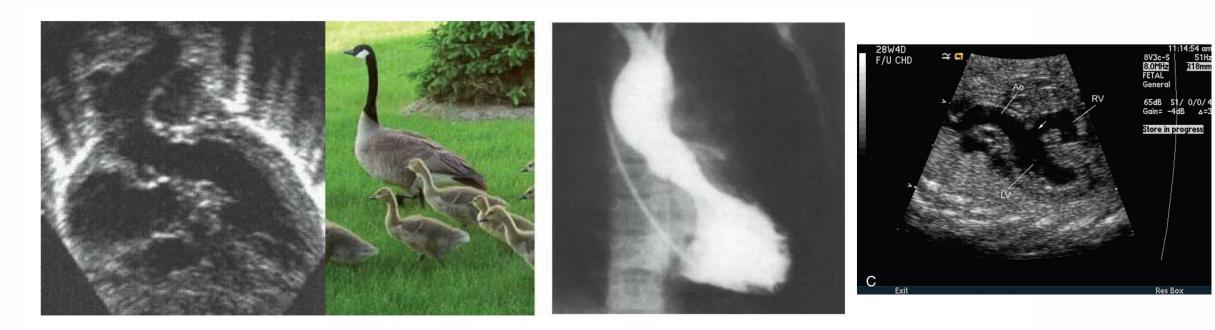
Gooseneck left ventricular outflow tract (LVOT) deformity in AVSD. Because of the anterior displacement of the LVOT in AVSD, the elongated LVOT has been described as a "gooseneck" with echocardiographic (left) and angiographic (right) imaging. Center: Pediatric and adult goosenecks in Minnesota.
